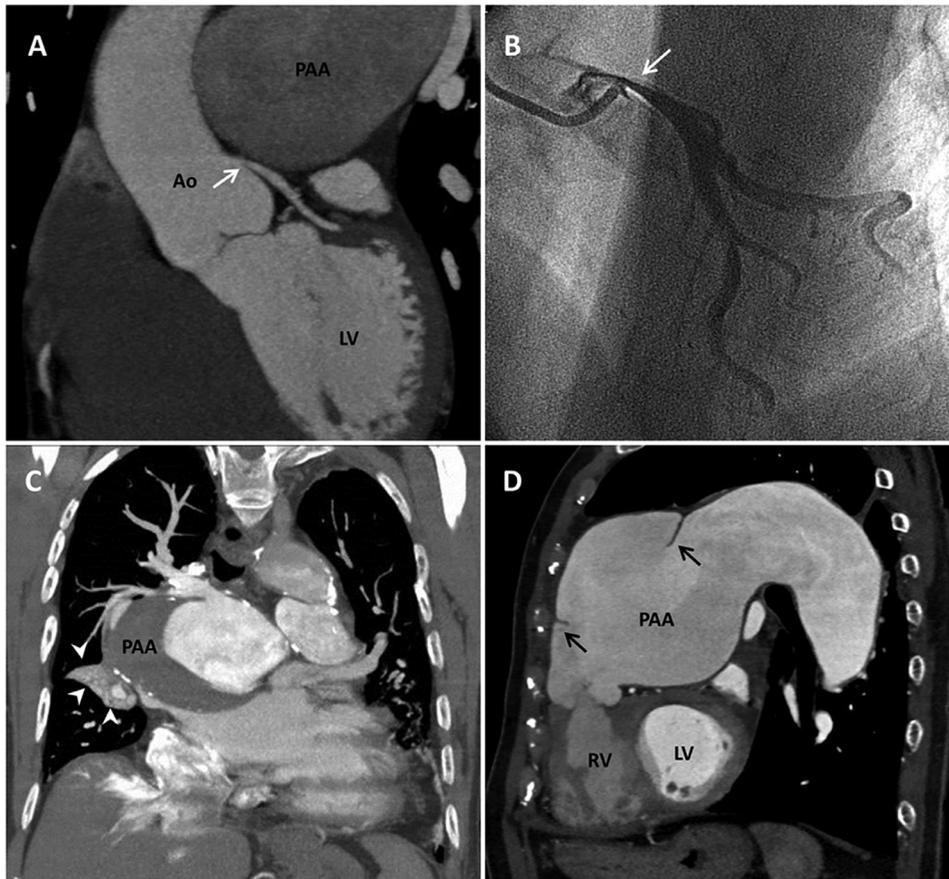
PAA-related complications. (A) CT coronary angiography oblique coronal view showing left main coronary artery compression (arrow) by a PAA; (B) coronary angiography demonstrating ostial left main coronary artery compression (arrow); (C) giant PAA with concomitant dilatation of right pulmonary artery compressing the right lung middle lobe (arrow heads); (D) PAA dissection (arrows). Ao = aorta; LV = left ventricle; PAA = pulmonary artery aneurysm; RV = right ventricle.
